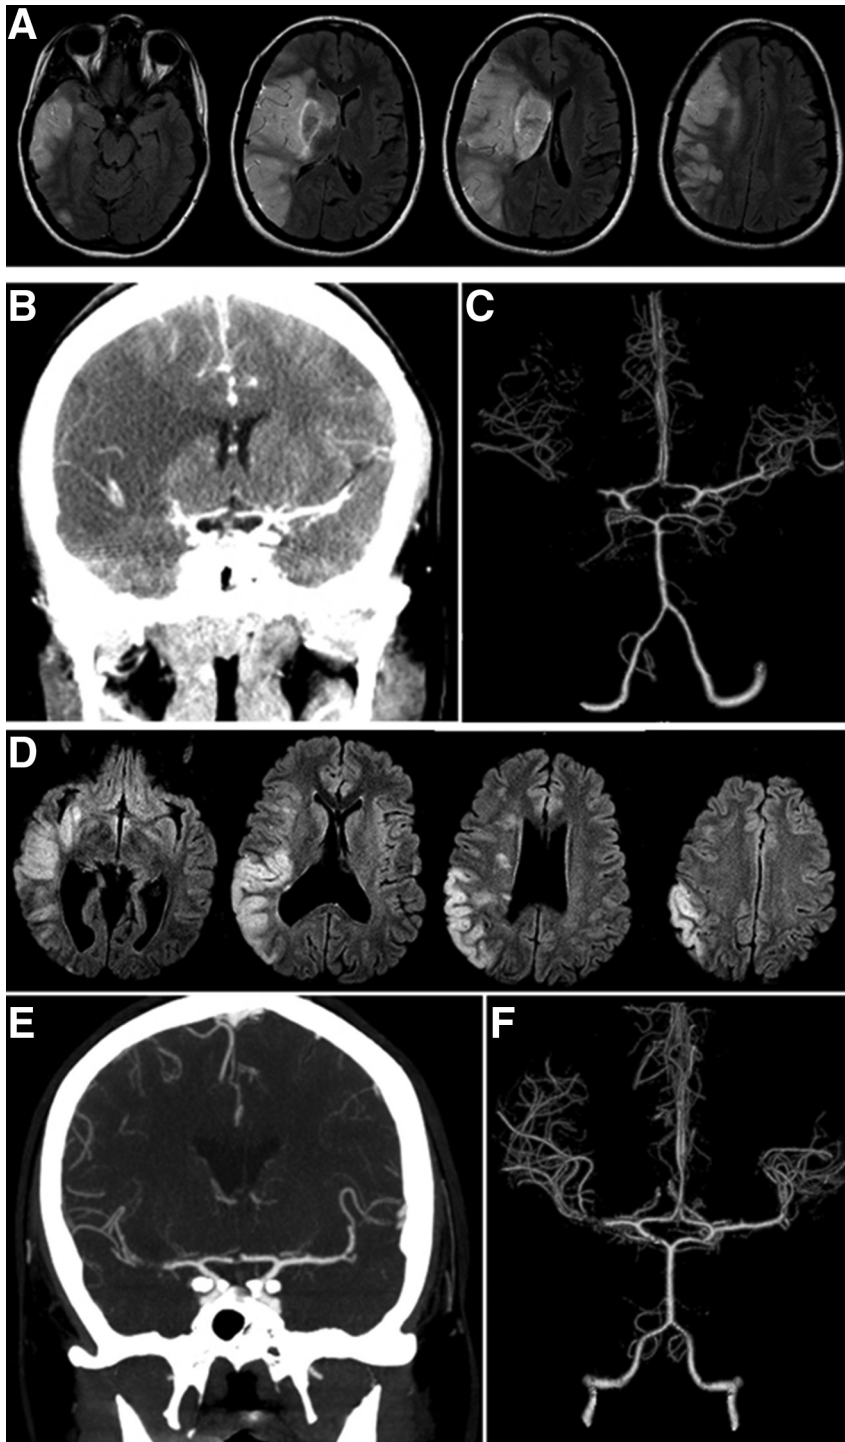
Case 1: Magnetic resonance imaging FLAIR sequence (A) showing near-complete infarction of right MCA territory, with corresponding occlusion on CT angiography (B and C). Case 2: MRI FLAIR sequence (D) showing infarction of predominantly inferior division right MCA territory, with corresponding occlusion on CT angiography (E and F). Abbreviations: FLAIR, fluid-attenuated inversion recovery; MCA, middle cerebral artery; MRI, magnetic resonance imaging.
